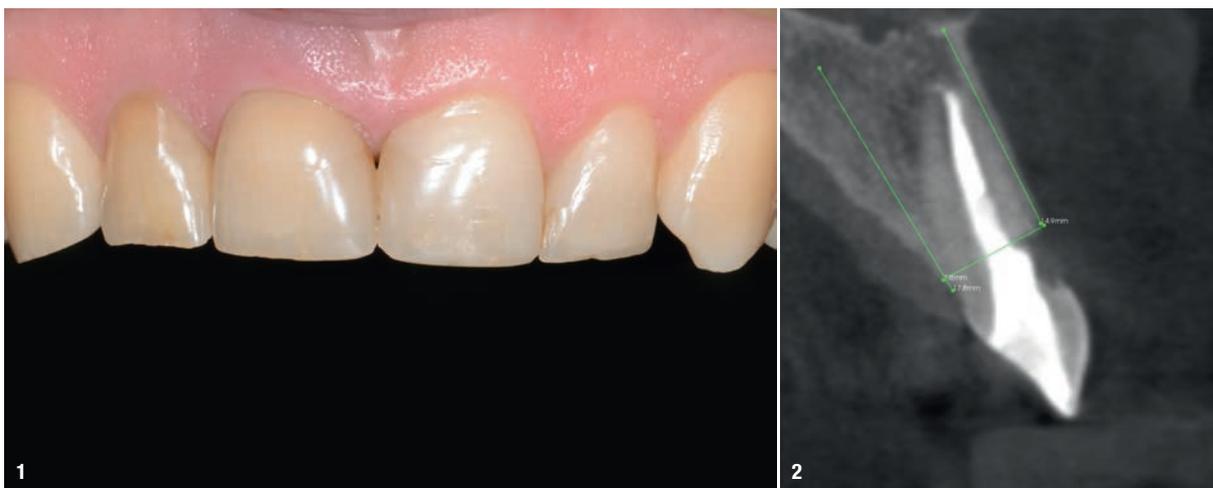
Situation before treatment, which led to the decision to extract tooth #11. Fig. 2: CBCT scan: the root of the tooth was visibly fractured, and there was clear external resorption of the root from the vestibular side.
